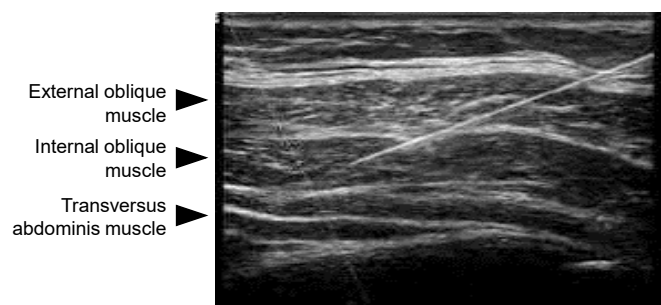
Ultrasound image of the needle approaching the TAP plane
